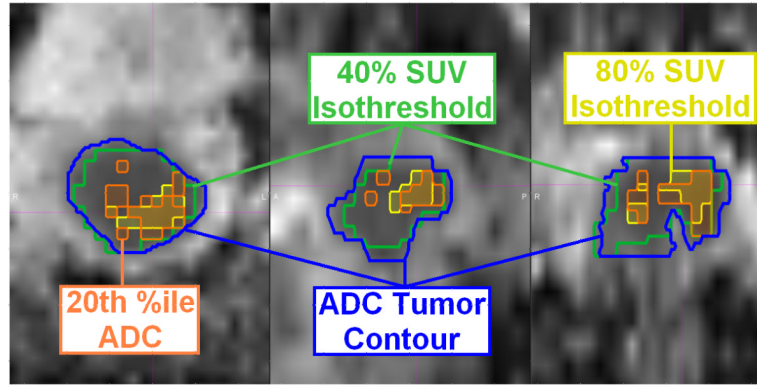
Example of imaging concordance between FDG-PET and ADC-MRI for one patient on axial (left), sagittal (center), and coronal (right) sections. The ADC map (blue) and FDG-PET (green) tumor contours are shown, with overlap observed between the 80% FDG-PET SUV isothreshold (yellow) and the 20th percentile ADC value (orange), indicative of the tumor subvolume with the most restricted diffusion, on the ADC map.
